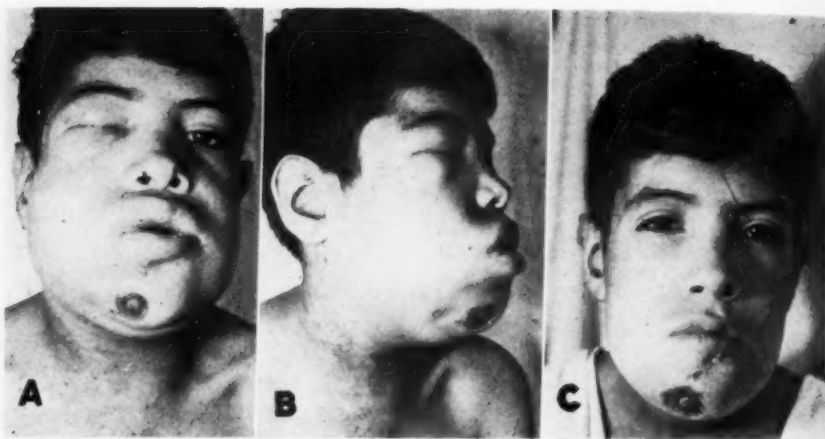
Case IV. A and B. Before roentgen treatment. C. Following treatment.
